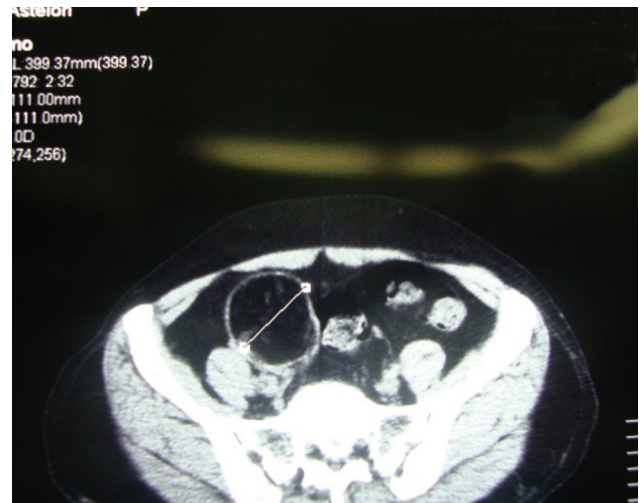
Pelvic CT scan showing more prominent view of the remnant of the left cyst.
